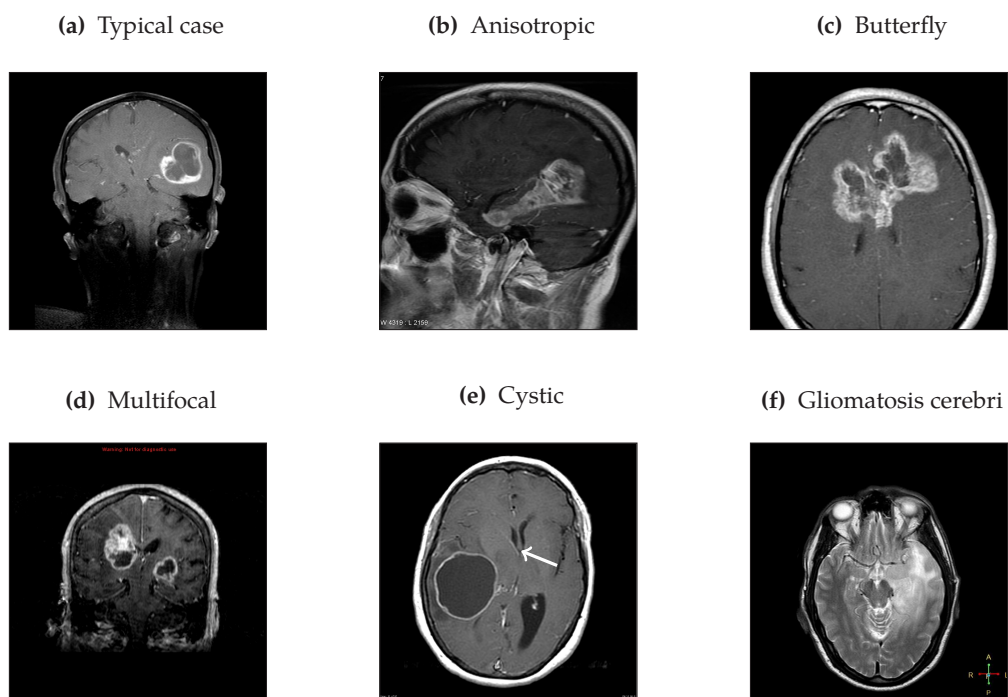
Growth patterns of GBM as seen on MRI. Figures 2.1a to 2.1d are contrast enhanced T1 images, Figure 2.1f is a T2 image. The white arrow (not in the original image) in Figure 2.1e points to visible mass effect. Images are taken from [Radiopaedia.org](https://radiopaedia.org). For full credits, see the Image Credits at the end of the document.
